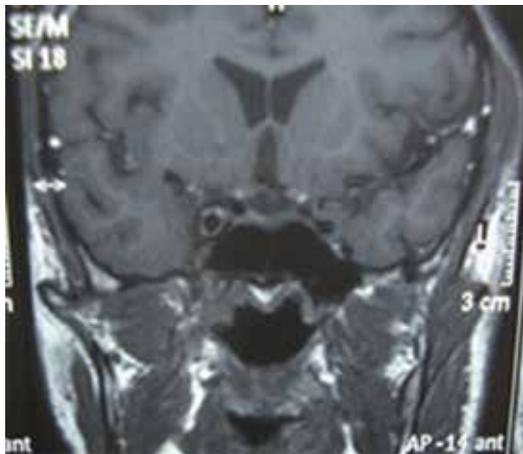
MRI coronal section showing compression of internal carotid artery.
